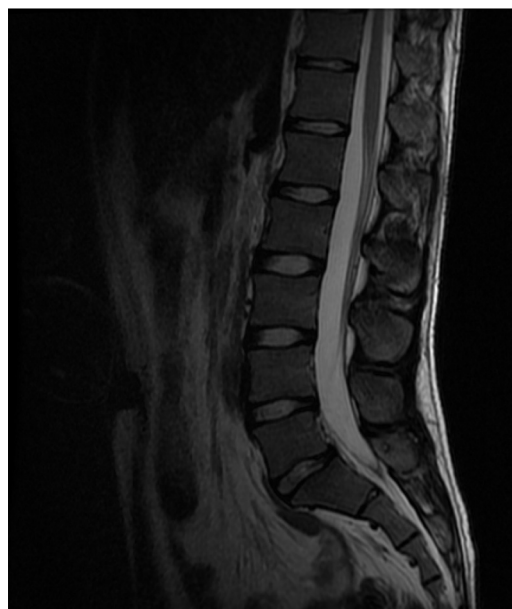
T2-weighted sagittal cut magnetic resonance image (MRI) of L-spine showing relatively normal disk anatomy at L4-5 and L5-S1 in patient with L5 pars defect.
